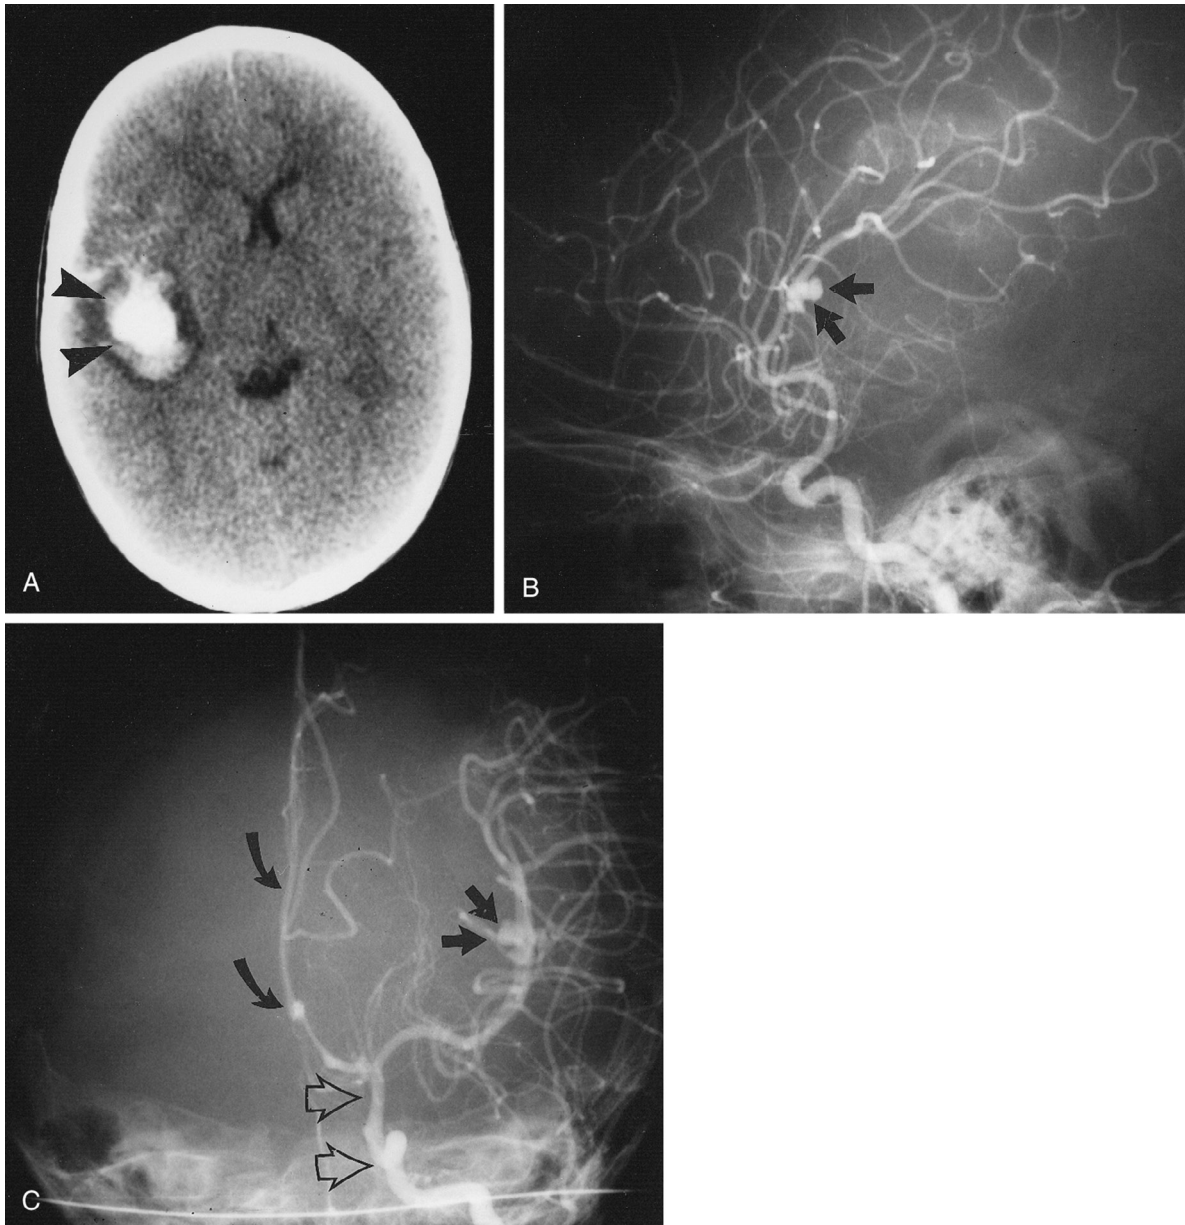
Mycotic Cerebral Aneurysm Hemorrhage. *A*, A cranial computed tomographic scan reveals a hyperdense area in the left temporal lobe (*arrowheads*) representing intraparenchymal hemorrhage. *B*, Cerebral angiography in a lateral view shows a lobulated structural abnormality representing the mycotic aneurysm, most probably residing in the middle cerebral artery tree (*arrows*). *C*, An anteroposterior angiographic view confirms the location of the aneurysm in the middle cerebral artery (*straight arrows*) located laterally rather than in the more medial anterior cerebral artery (*curved arrows*). The internal carotid artery (*open arrows*) gives rise to both the anterior and the middle cerebral arteries.
